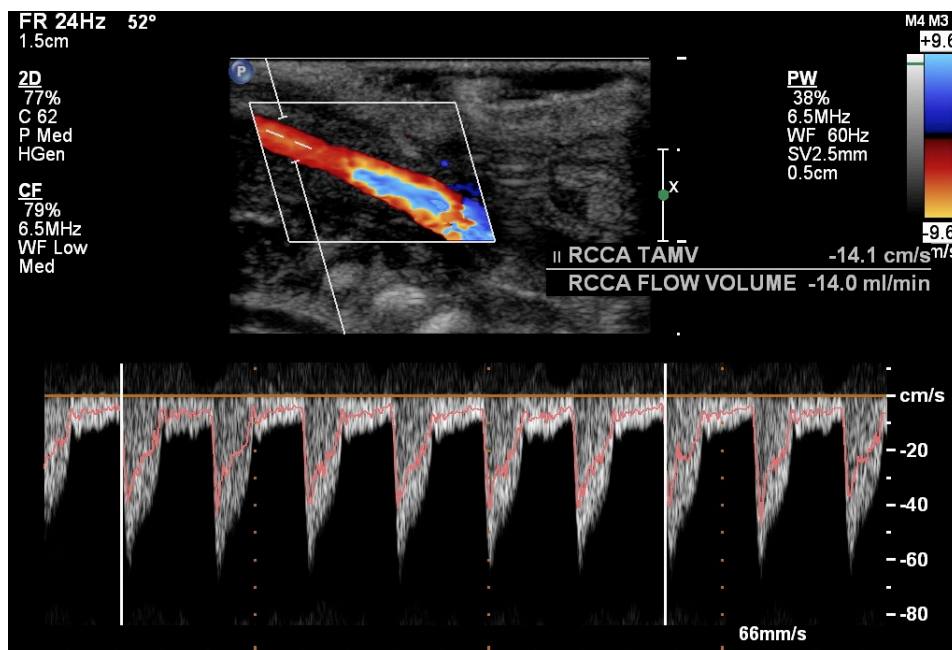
Longitudinal view of the right common carotid artery with the Doppler sampling gate placed in the artery. The time averaged mean velocity was calculated from 6 artefact free waveforms.
